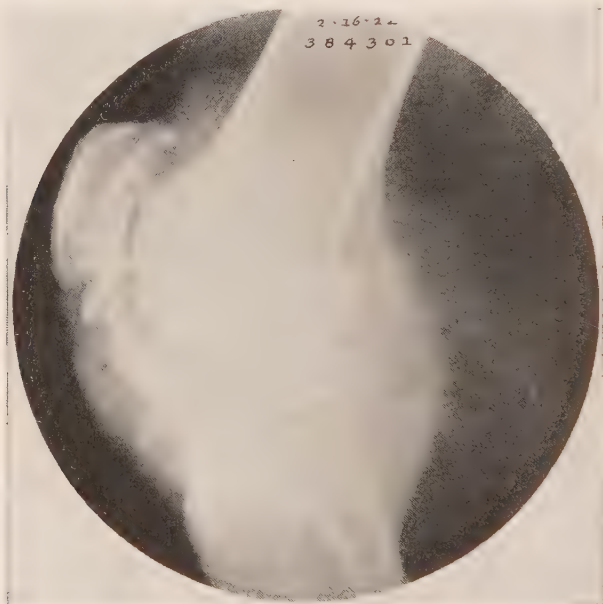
Typical Charcot knee (Stokes). Roentgenogram of knee shown in Fig. 195.
